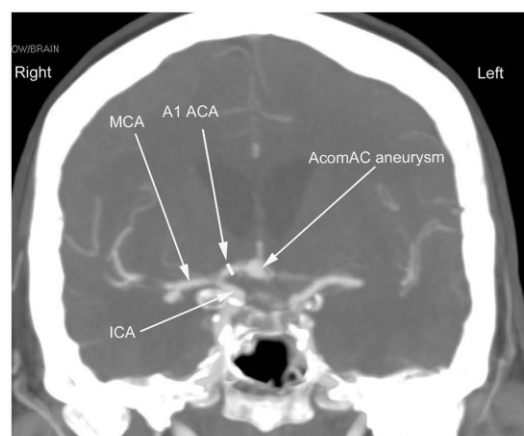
Cerebral CT Angiography scan with AcomAC aneurysm in coronal view, white line perpendicular to the long axis of the vessel (A1 ACA) indicates measurement site. A1 ACA, the first part of anterior cerebral artery; AcomAC=anterior communicating arterial complex; ICA, internal carotid artery; MCA, middle cerebral artery.
